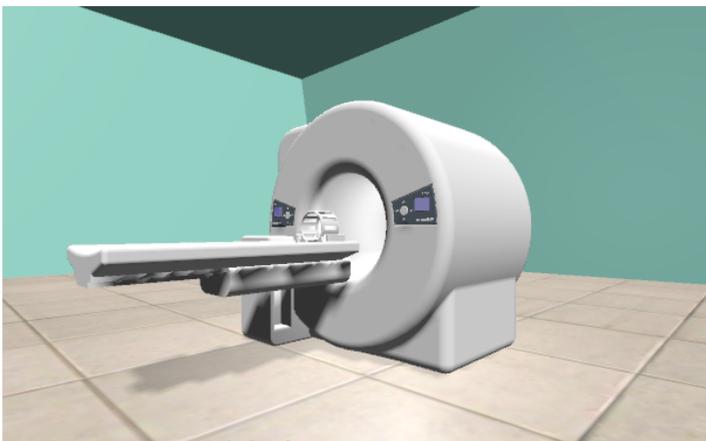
3D model of MRI scanner in Unity programming
